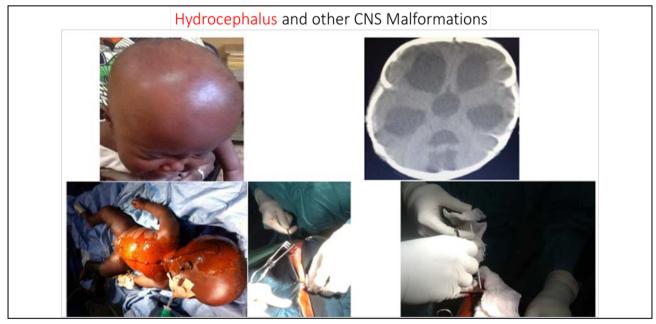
CT and intraoperative mages of patient with hydrocephalus and ventriculoperitoneal shunt insertion.
